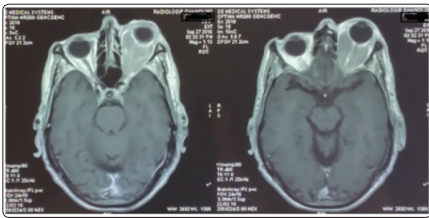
Cranio-orbital MRI showing an intra-orbital left orbital lesion process
